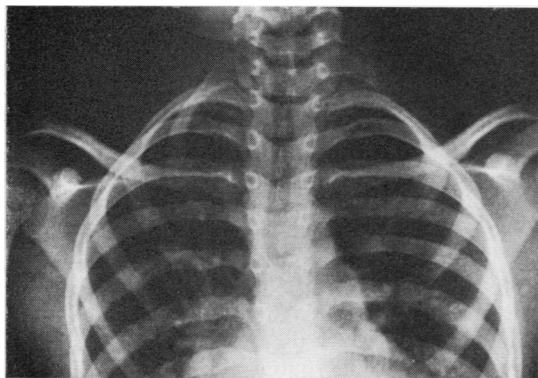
Radiograph showing hypoplastic left first rib.
